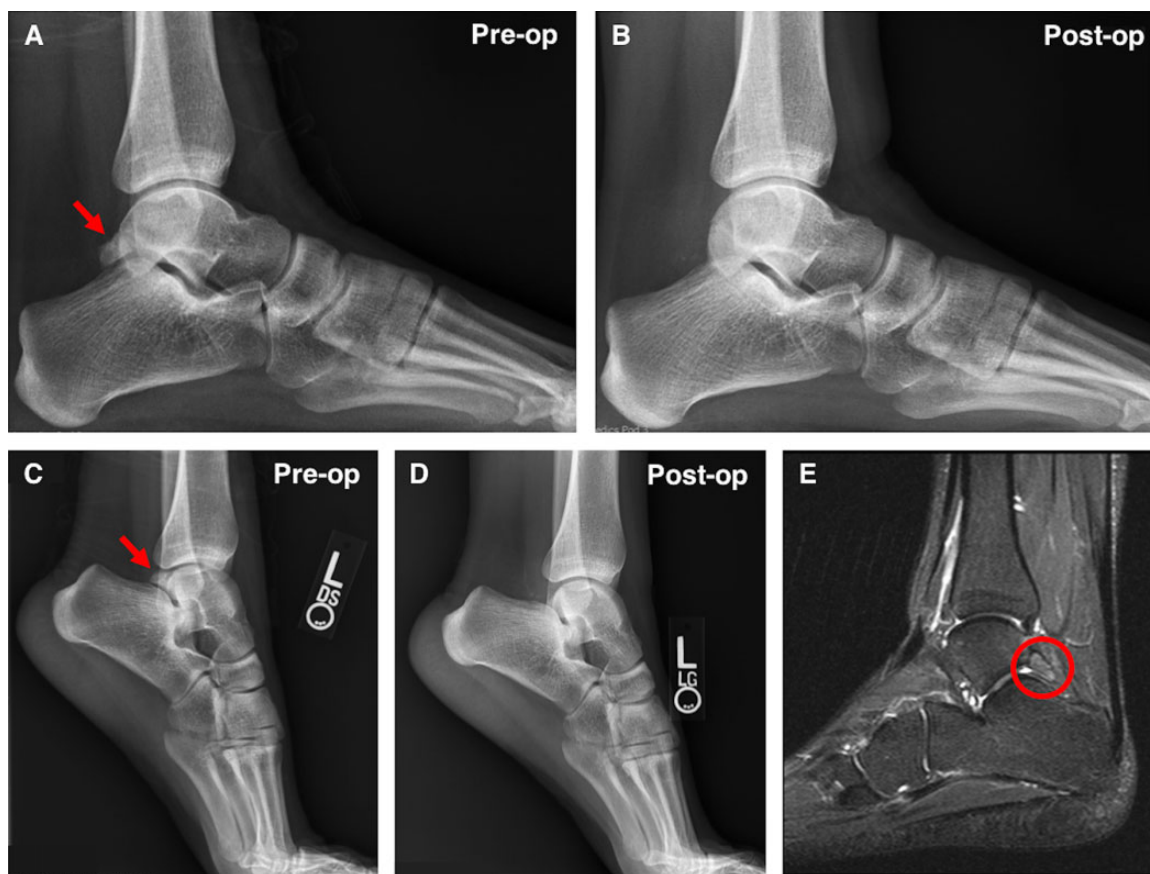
Imaging characteristics of a symptomatic os trigonum. Imaging was obtained upon positive clinical indication of posterior ankle impingement, represented here in a single dancer included in the study. (A) Lateral weightbearing radiographs obtained preoperatively revealed an os trigonum posterior to the talus (red arrow) compared with that obtained from (B) surgical excision at 6-month follow-up. Additionally, (C) demi-pointe lateral radiograph of the same dancer showed restriction of normal plantarflexion compared with that obtained (D) after follow-up. (E) Magnetic resonance imaging was used to further evaluate the size of the ossicle (red circle), as well as focal edema in the hindfoot of soft tissue structures being impinged.
